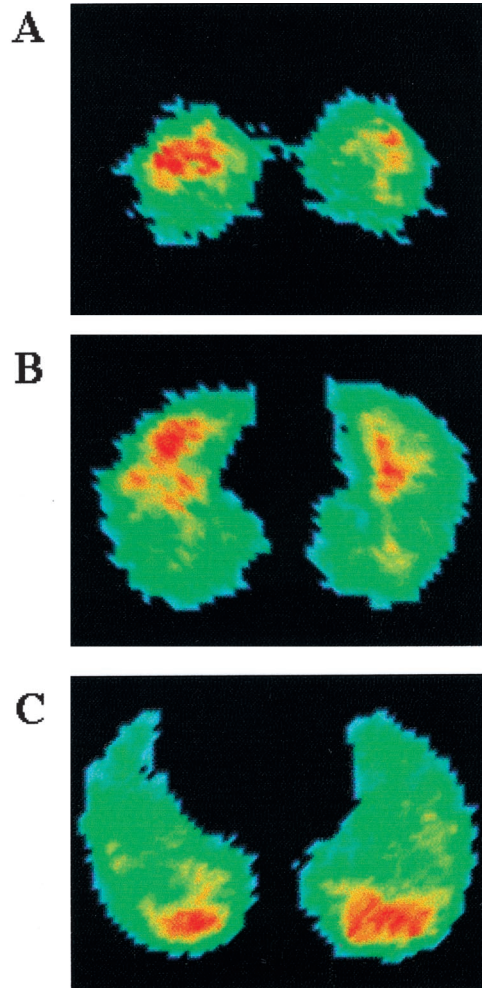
Single-photon-emission computed tomography (SPECT) images obtained at transverse locations approximately (A) 19 cm, (B) 13 cm, and (C) 5 cm from the base of the lungs.
